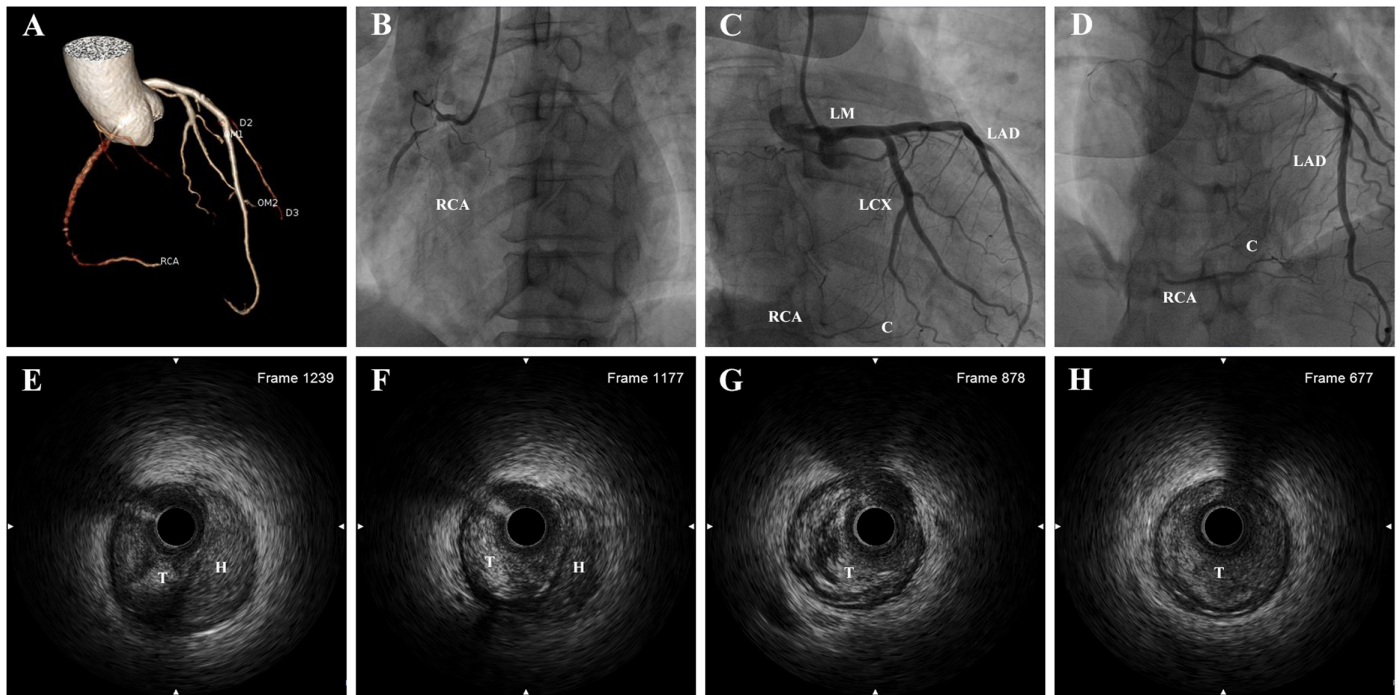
Computed tomographic angiography (A) shows severe occlusion in the proximal RCA with apparently normal left coronary arteries. Invasive coronary angiography demonstrates a severely occluded RCA (B), with coronary collaterals from the left coronary arteries (C, D). Intravascular ultrasound imaging of the RCA shows a large intramural hematoma in the proximal stenotic segment and luminal thrombosis (E, F) with partial recanalization in the distal stenotic segment (dark area, G, H). C, coronary collaterals; H, hematoma; LAD, left anterior descending coronary artery; LCX, left circumflex coronary artery; LM, left main coronary artery; RCA, right coronary artery; T, thrombi.
